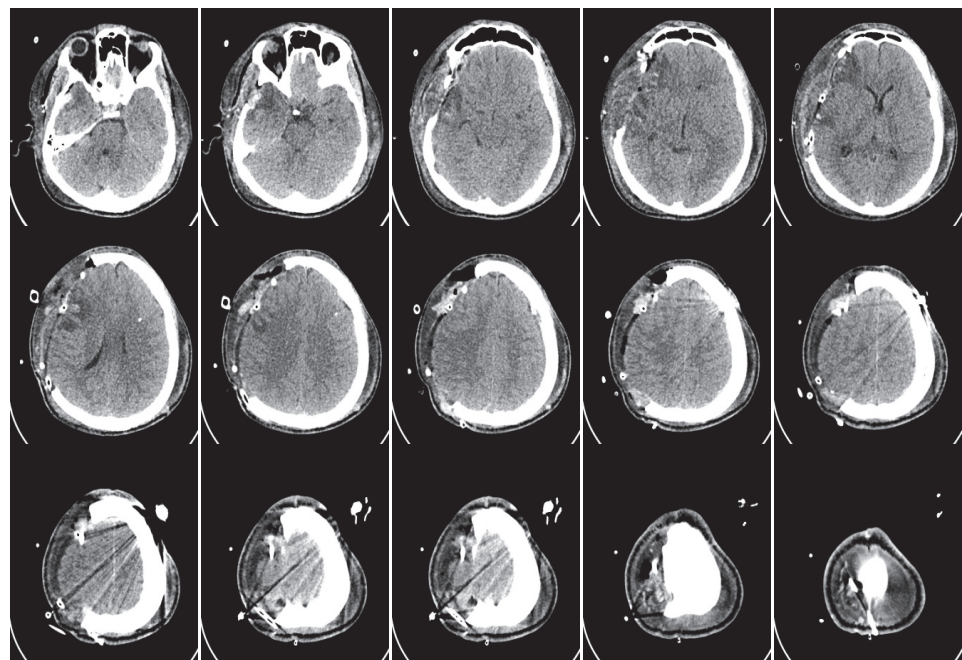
CT scan images of patient with multiple bone fracture
